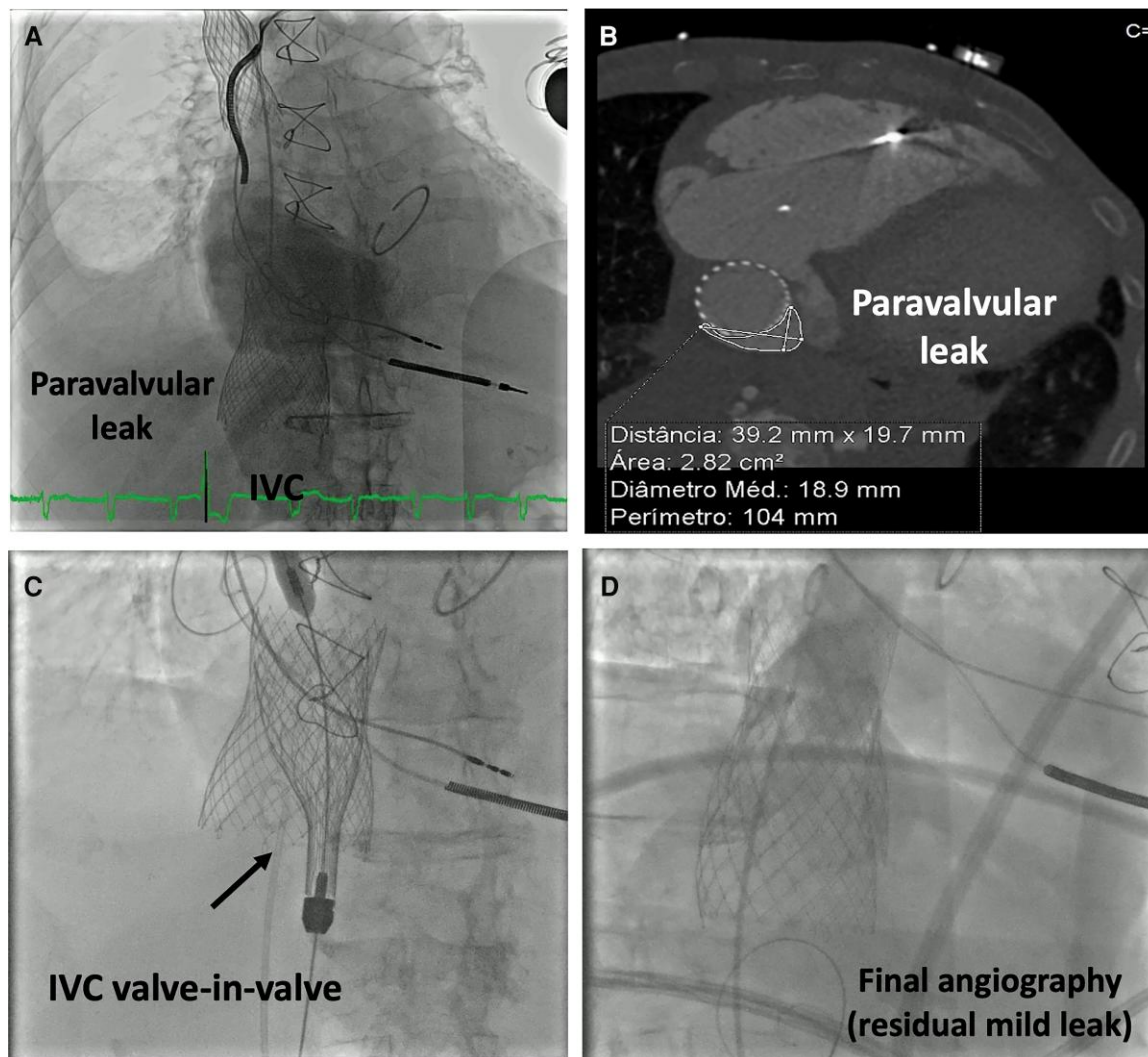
Paravalvular leak and re-intervention of Patient 1. (A) Venography performed during decompensated heart failure re-admission showing a major peri-valvular leak in the inferior vena cava prosthesis. (B) Cardiac computed tomography angiography to assess the leak dimensions in order to plan the valve-in-valve re-intervention, where a 35 mm valve was selected. (C, D) Valve-in-valve procedure using a 35 mm inferior vena cava caval prosthetic valve (black arrow) and final venography after valve release showing only a mild residual leak.
